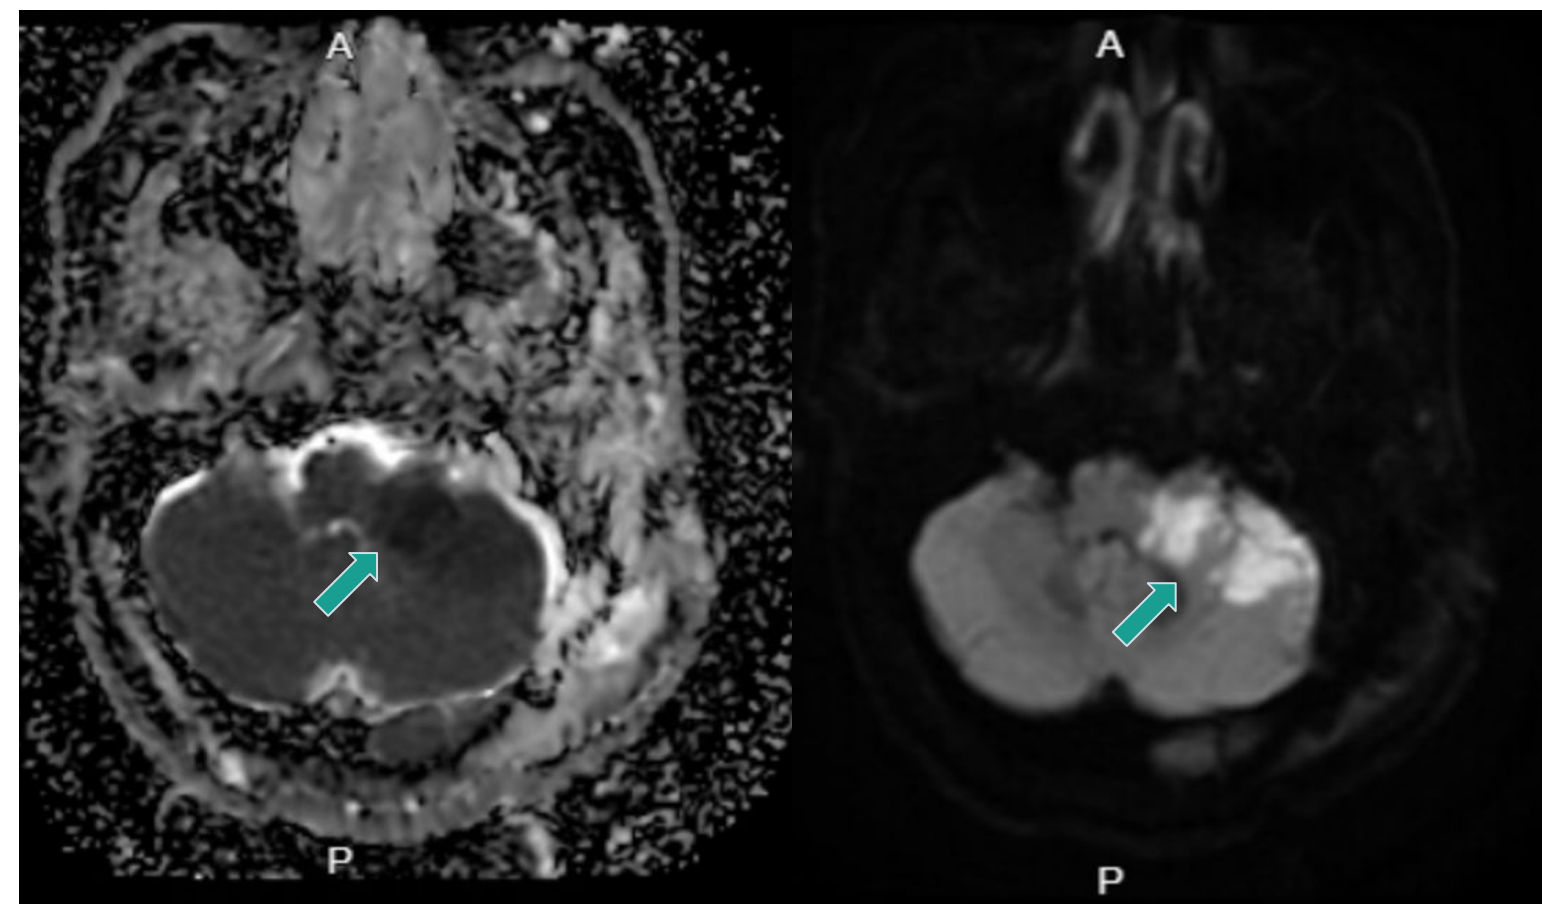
Post-surgical MRIs - Left: ADC, Right: DWI
